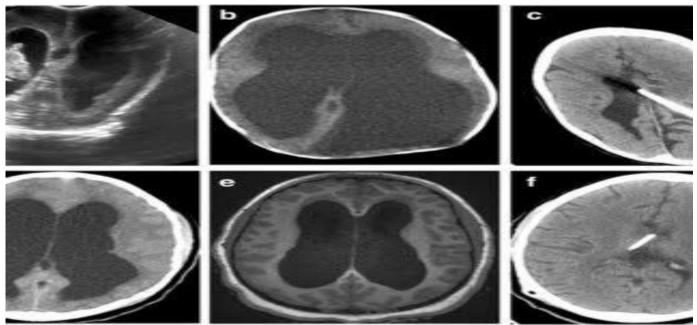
Male infant aged 3 Months, admitted to NICU with dehydration + Vomitting, CT brain showed inter ventricular Hge. Management: After 3 follow up V.P SHUNT, Pre operation (a,b,c,d,e) and Post operation (f).
